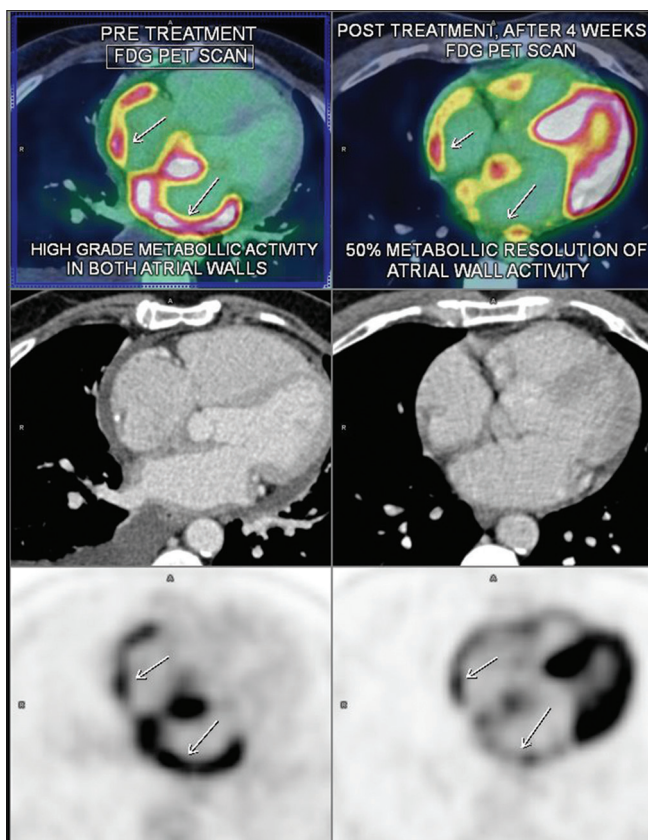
Pretreatment fluorodeoxyglucose positron emission tomography and computed tomography scan (on the left) shows high-grade metabolic activity in both atrial walls, interatrial septum with extensive left atrial wall involvement, posttreatment scan (on the right) shows about 50% decrease in the metabolic activity along the right and left atrium
